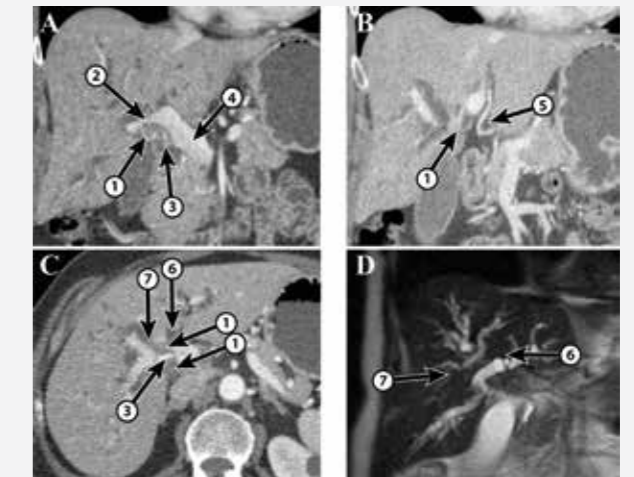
The tumour is in close contact with the right portal vein and encapsulates the right hepatic artery. In A, the tumour is affecting the right hepatic artery and the right portal branch. The portal vein is not affected. In B, the non-affected left hepatic artery is shown. In C, the affected right hepatic artery surrounded by the tumour is shown. D is a cholangio-MRI of the tumour and shows its relation to the left and right hepatic duct (without affecting secondary branches). (1) Tumour; (2) right portal; (3) right hepatic artery; (4) portal vein; (5) left hepatic artery; (6) left hepatic duct; (7) right hepatic duct.
